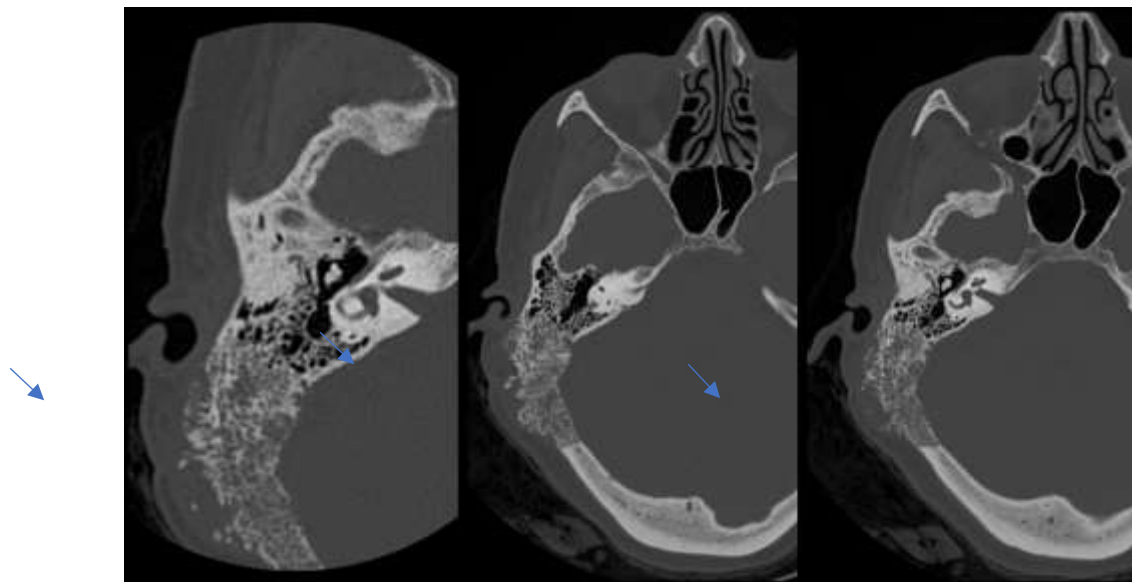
Axial CT slices passing through the base of the skull, revealing an osteolytic lesion of the right mastoid, breaching both the inner and outer cortical layers, with thickening of the bony trabeculae and a periosteal reaction adjacent to the lesion, without
